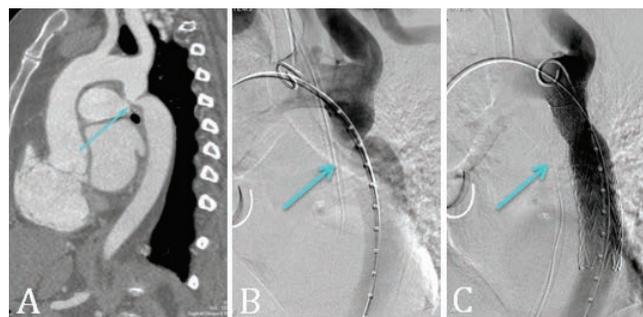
CT angiogram (A) and initial intraoperative aortogram (B) showing the aortic coarctation. Completion angiogram (C) following deployment of the aortic stent graft, with resolution of the stenosis.
